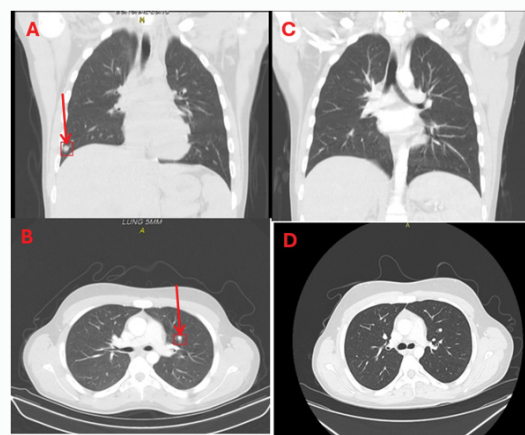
Resolution of the nodules found on Pre-treatment CT scan; (A&B: CT chest before treatment, C&D: CT chest after completion of the 7th Cycle of individualised treatment.
